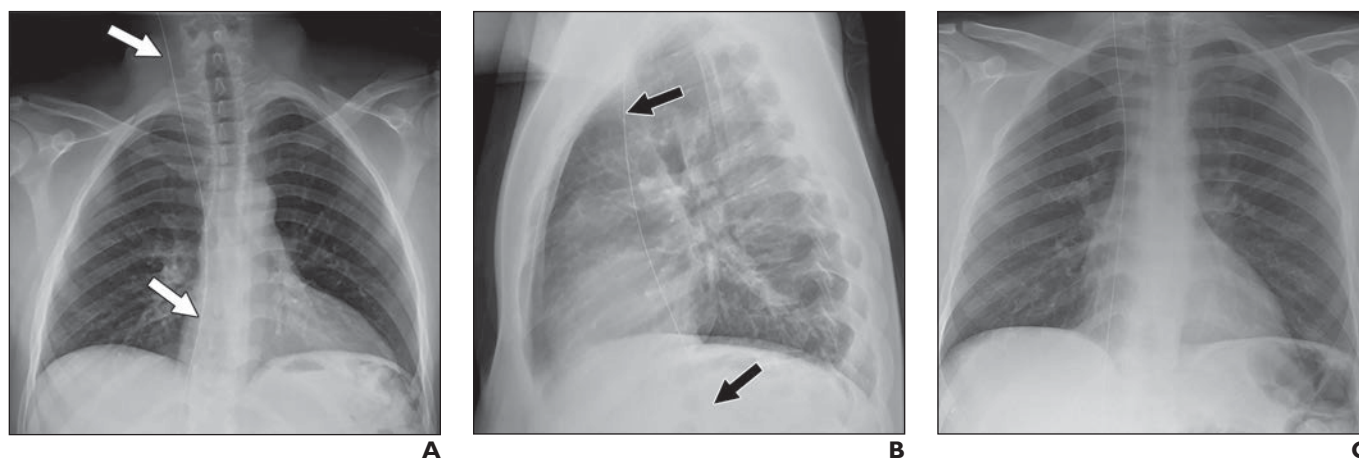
Prevalence effect and alliterative error. A and B, Posteroanterior (A) and lateral (B) chest radiographs of 20-year-old man who presented with cough, fever, and chest pain. Official interpretation was right-sided ventriculoperitoneal (VP) shunt (arrows). C, Repeat posteroanterior chest radiograph obtained weeks after A and B was interpreted as “unchanged right-sided VP shunt.” However, structure is too medial, lacks lumen, and is not in subcutaneous tissues (A) as would be expected with shunt. Findings are consistent with retained guidewire. Interventional radiologist retrieved guidewire, confirming diagnosis. In most cases, thin line overlying patient on frontal view is VP shunt and is therefore first consideration (low prevalence effect). Cognition needed to note correct nature of this finding may not be given in time-pressured environment. Interpretation of repeat chest radiograph deferred to opinion of prior reader (alliterative error).
